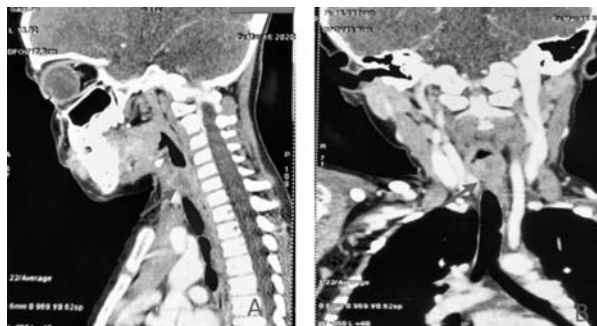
Contrast-enhanced computed tomography images (sagittal view: A and coronal view: B) showing an elongated mildly enhancing soft tissue mass seen in the glottic and subglottic larynx, extending from the level of posterior commissure at true glottis level and extending inferiorly into the posterior subglottic region, causing marked narrowing of subglottic airway.
